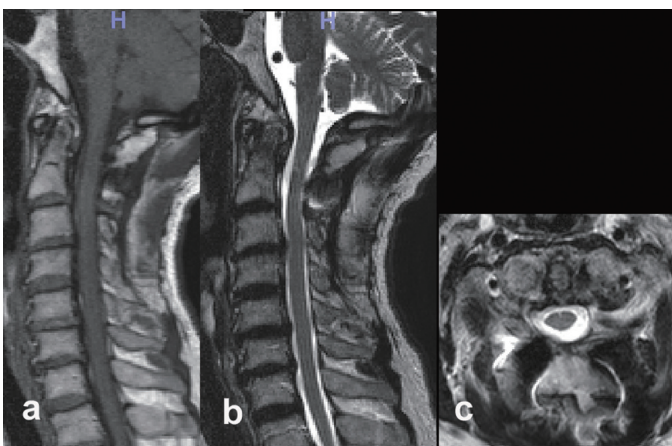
Postoperative MRI (a: T1-weighted image, b: T2-weighted sagittal image, c: T2-weighted axial image) showing resolution of the pseudotumor and decompression of the spinal cord.
